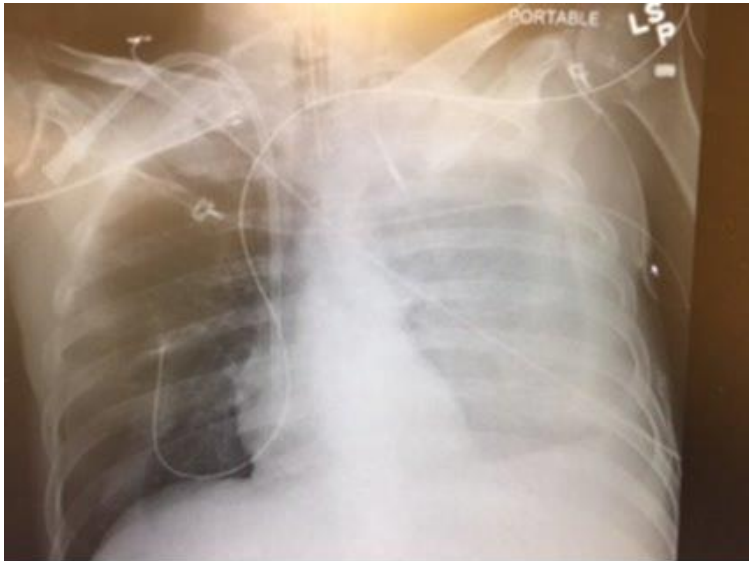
Chest X-ray of displaced CVL
